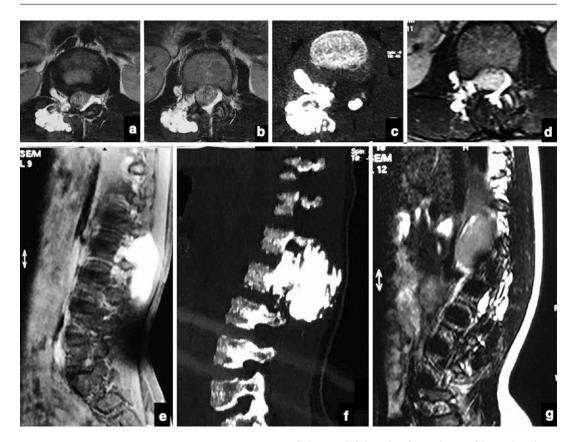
Ten–year-old girl with backache and dragging sensation. No obvious swelling was seen on examination. (\mathbf{a} and \mathbf{b}) Spinal MRI axial section at L1–L2 level showed right paraspinal venous malformation. The lesion is extending along the right dorsal nerve root (\mathbf{e}) Sagittal image showing the longitudinal extent of the lesion. Percutaneous sclerotherapy was done in GA in prone position using 18G spinal needle. USG standby helps in locating the lesion when selling is not obvious.
